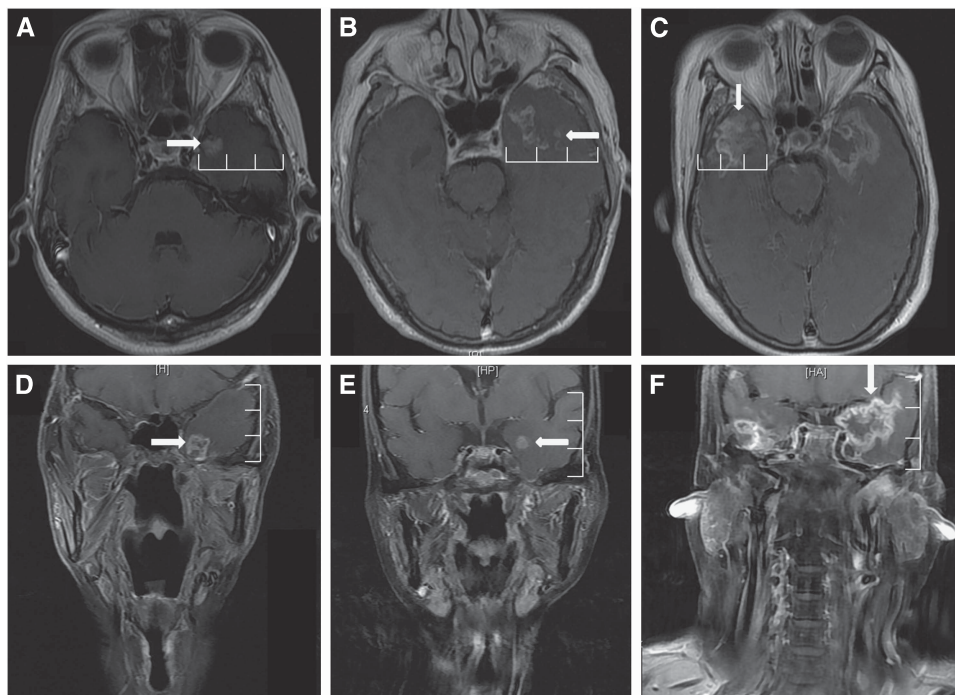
Post-contrast, T1-weighted magnetic resonance images show the extent of contrast-enhanced lesions in both the mediolateral and superoinferior directions. (A) Contrast-enhanced lesions (rightward arrow) within the medial 1/3 of the ipsilateral temporal lobe in an axial image. (B) Contrast-enhanced lesions (leftward arrow) extending beyond the medial 1/3 but not reaching the lateral 1/3 of the ipsilateral temporal lobe in an axial image. (C) Contrast-enhanced lesions (downward arrow) reaching the lateral 1/3 of the ipsilateral temporal lobe in an axial image. (D) Contrast-enhanced lesions (rightward arrow) within the inferior 1/3 of the ipsilateral temporal lobe in a coronal image. (E) Contrast-enhanced lesions (leftward arrow) extending beyond the inferior 1/3 but not reaching the superior 1/3 of the ipsilateral temporal lobe in a coronal image. (F) Contrast-enhanced lesions (downward arrow) reaching the superior 1/3 of the ipsilateral temporal lobe in a coronal image.
